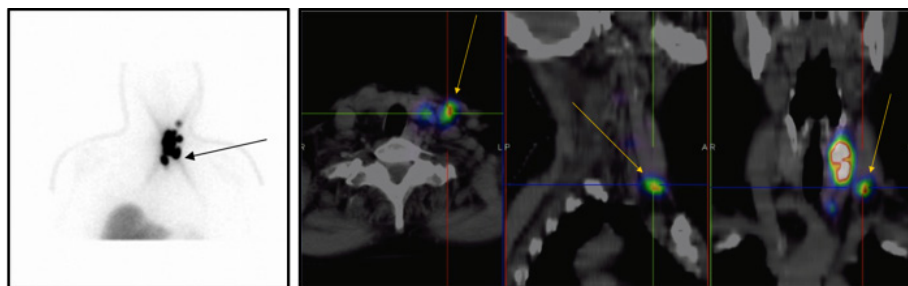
SLNM in a 75 year old woman with papillary microcarcinoma of the left thyroid lobe. Left: Anterior planar view obtained 2 h after US guided intratumoural injection of  $^{99m}\text{Tc}$  nanocolloid; radioactivity accumulation in the liver indicates passage of some radiocolloid into the general circulation at this relatively late time point post-injection. The injection site corresponds to the area with greatest radioactivity accumulation just left of the midline; multiple SLNs are visualized in the left cervical region, but the arrow points to the node with the highest radiocolloid uptake, also visualized as the first draining node on prior sequential imaging (the primary SLN). Right: Fused SPECT/CT sections (transaxial, sagittal and coronal) showing more accurately than planar imaging the exact topographic location of the primary SLN (indicated by yellow arrows, in level IV). Images courtesy of L. Feggi and S. Panareo, Nuclear Medicine Service, University Hospital, Ferrara, Italy.
